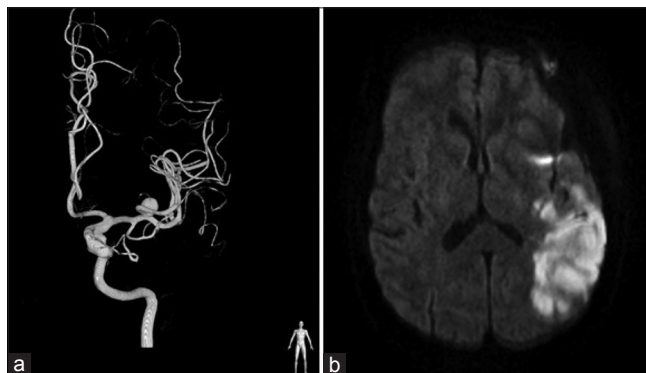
Pre- and post-operative images of a 50-year-old female with incidentally discovered left middle cerebral artery aneurysm. Following the MPT she developed expressive aphasia as such she was readmitted and aspirin was initiated following the confirmation of the infarction. The patient's speech subsequently gradually improved after aspirin therapy. (a) Three-dimensional angiogram of left internal carotid artery demonstrating a left middle cerebral artery bifurcation aneurysm. (b) Postoperative magnetic resonance imaging (diffusion weighted imaging) of the same patient showing areas of restricted diffusion consistent with ischemia and infarction of the left posterior middle cerebral artery territory
